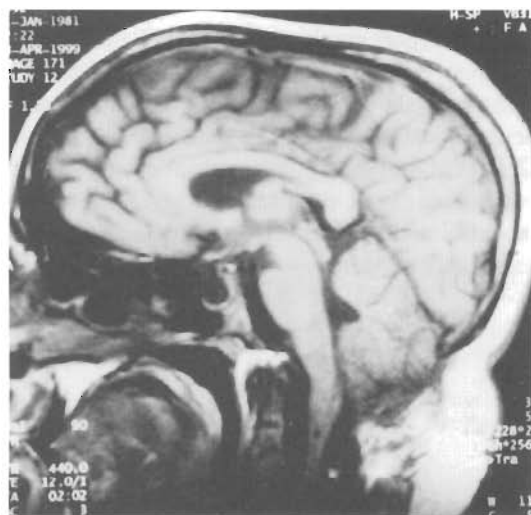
Postoperative MRI demonstrates decompression of the posterior fossa, cerebellar tonsils and improvement of the cervical syrinx.
